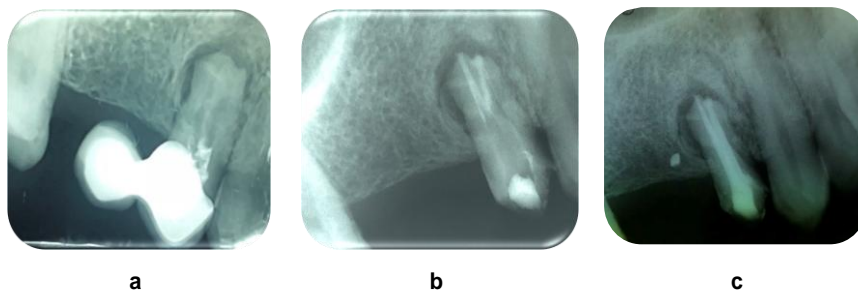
Pre-operative radiograph of 14 (a), after placement of MTA apical plug (b), post-operative radiograph following obturation of 14 (c)
